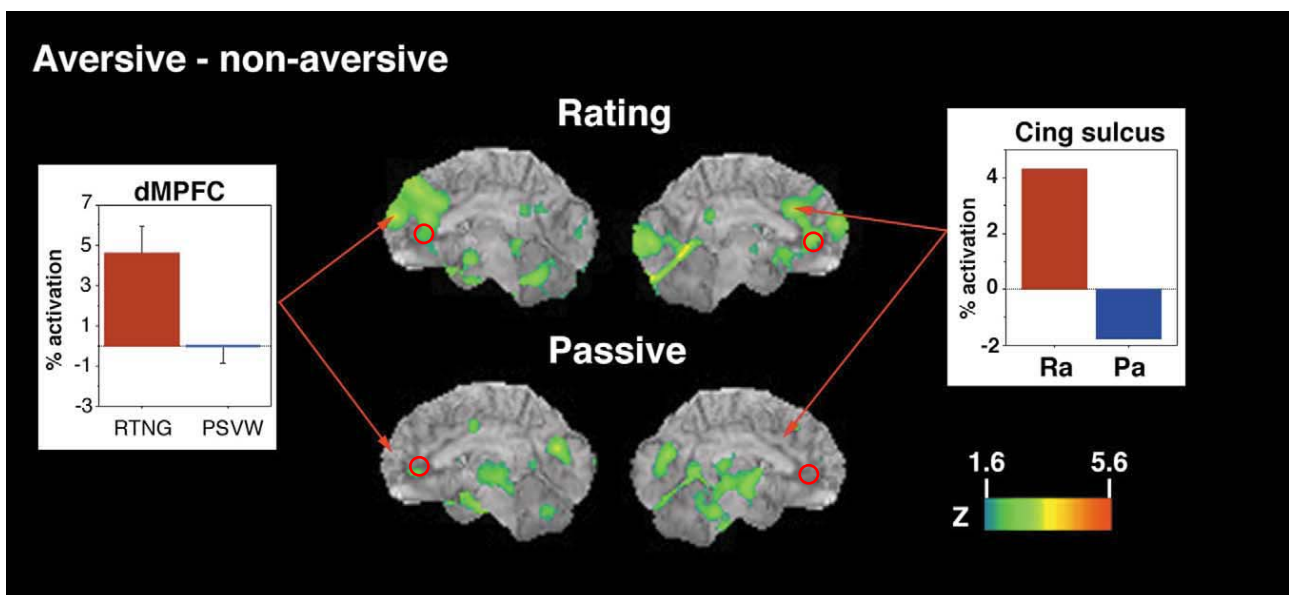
Activation foci are mapped onto the right mesial surface (left column) and left medial surface (right column) surface renderings of a reference MRI brain in Talairach and Tournoux coordinates (figure from from S.F. Taylor et al. / *NeuroImage* 18 (2003) 650–659). The approximate y and z coordinates of the emotional deactivation, demonstrated by Geday et al (2003, 2007) are indicated by the red circles.
